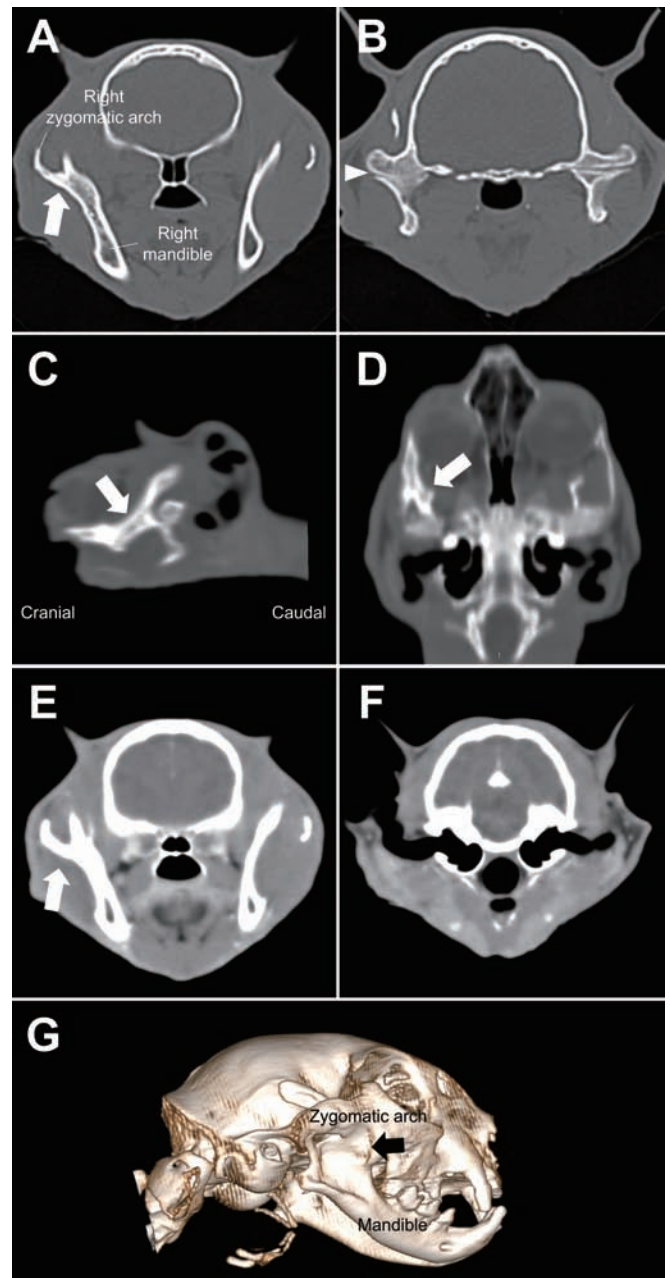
The computed tomography (CT) transverse plane images (A, B), sagittal image (C), dorsal plane image (D) of the patient's skull (window level = 350, window width = 2,700). (A, C, D) The abnormal union (white arrow) between the right zygomatic arch and the right mandible was confirmed. (B) The temporomandibular joint space narrowing (white arrowhead) was also confirmed. (E, F) Transverse CT cross-sectional images were visualized with different window levels and window widths compared to (A, B, C, D) for soft tissue assessment. (E) There are no distinct abnormalities observed in the surrounding soft tissues, except for the abnormal union (white arrow). (F) No specific findings are identified in adjacent structures such as the tympanic bulla, brain, and pharynx. (G) The 3D CT reconstruction model image of the skull. The abnormal union (black arrow) is clearly visible in the 3D image.
